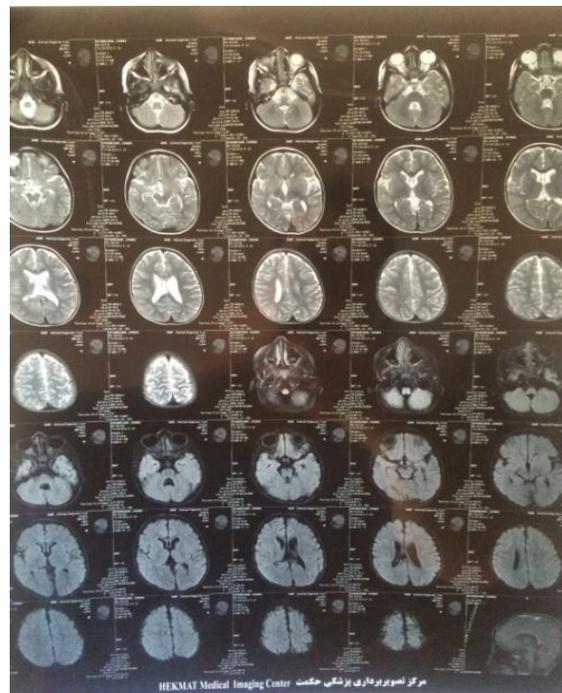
Computed tomography of the brain
